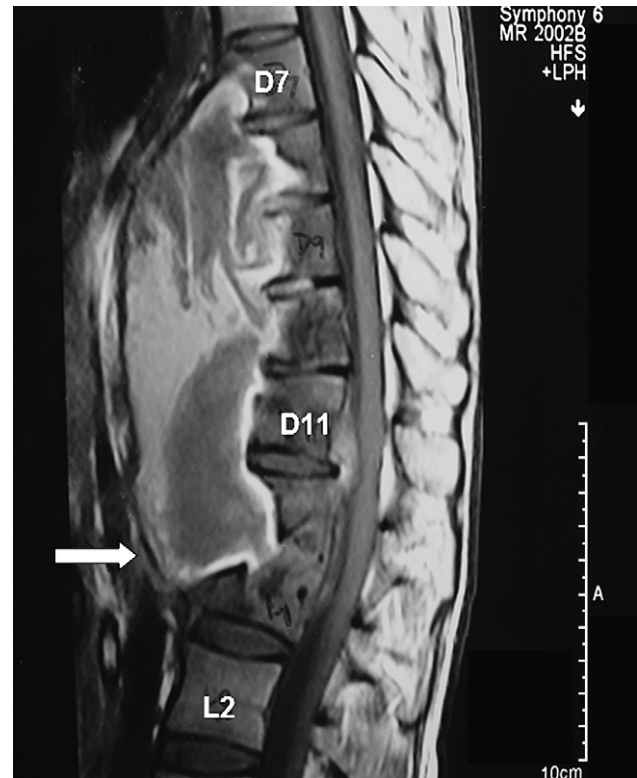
Four months follow-up magnetic resonance imaging (T1-weighted imaging) showing resolution of signal void lesion seen in Fig. 2.
